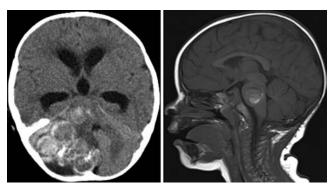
Case 2. Left: Axial noncontrast CT scan demonstrating a hemorrhagic posterior fossa mass with obstructive hydrocephalus and brainstem compression. Right: Postoperative sagittal T1-weighted noncontrast MR image revealing a residual brainstem CCM.
